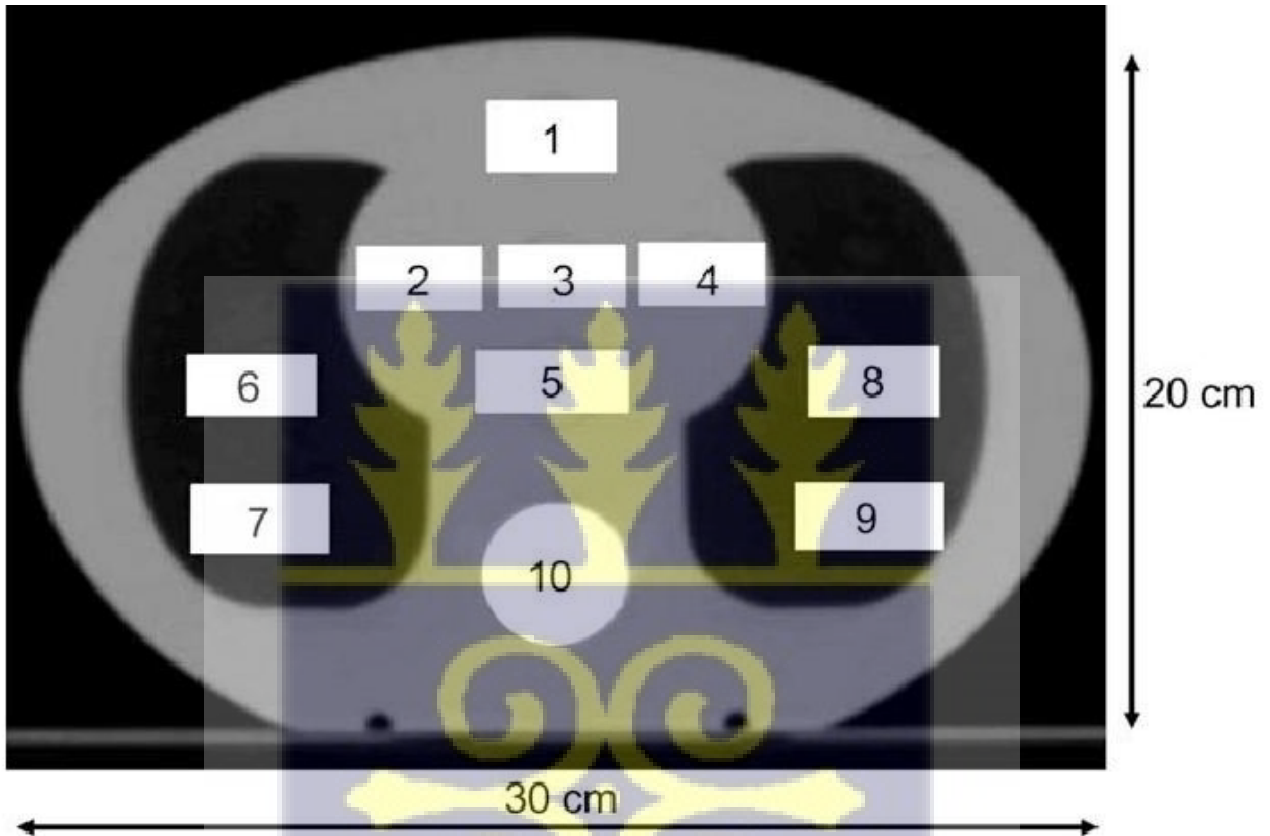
The recommended configuration for the CT scan's certified electron density reference plugs. (IAEA TECDOC 1583).
